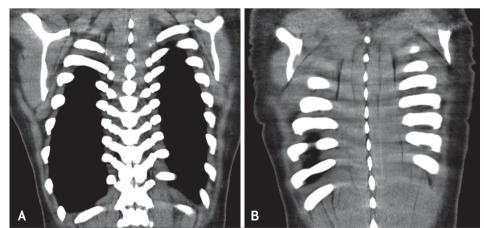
Computed tomography of the chest at the mediastinum window (level 40 and width 350 Hounsfield units) revealing diffusely homogenous marked hyperdensities of all bony structures. (A) Mid-coronal plane. (B) Posterior coronal plane.
